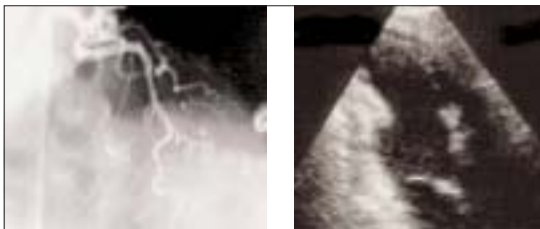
Forty-eight hrs follow-up coronary angiography (left) showing the persistence of an optimal epicardial patency. Myocardial contrast echocardiogram (right) revealing the disappearance of a significant contrast enhancement in the risk area.
